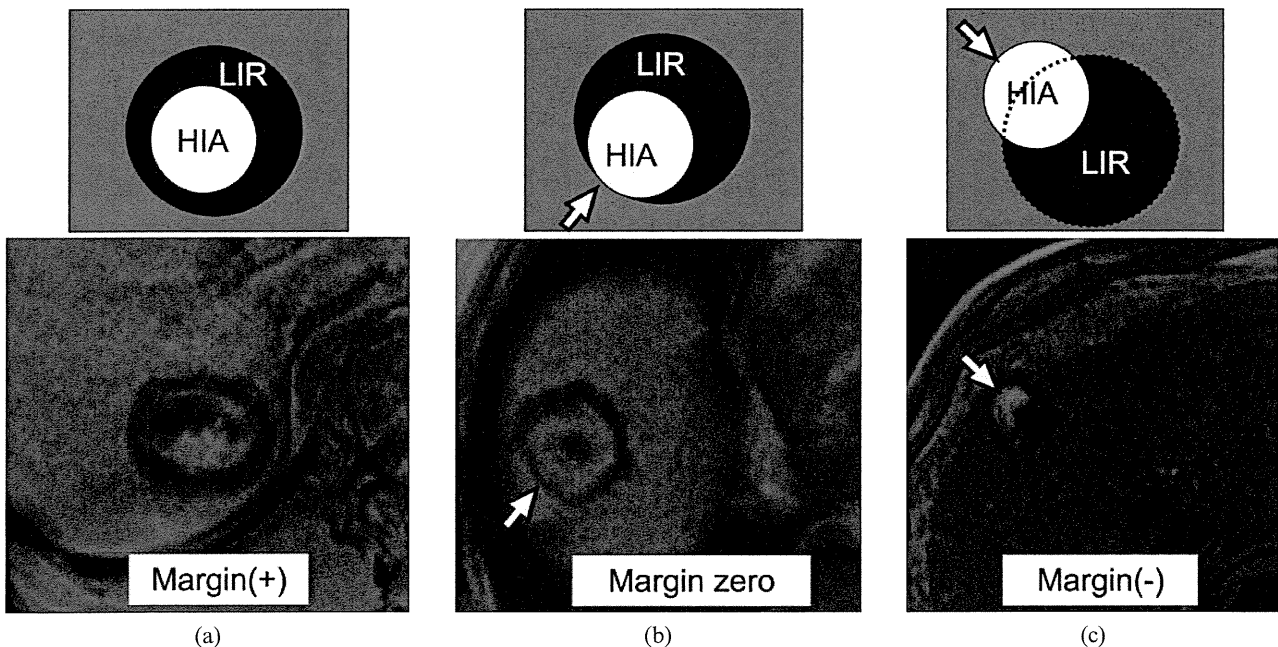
Grades of radiofrequency ablation treatment efficacy by post-ablational MRI. (a) Margin (+): high-intensity area (HIA) is contained within the low-intensity rim (LIR) and a continuous LIR is seen around the nodule. (b) Margin zero: HIA does not extend beyond the LIR, but the LIR is partially discontinuous (arrow). (c) Margin (-): discontinuous LIR with protrusion of HIA (arrow).
